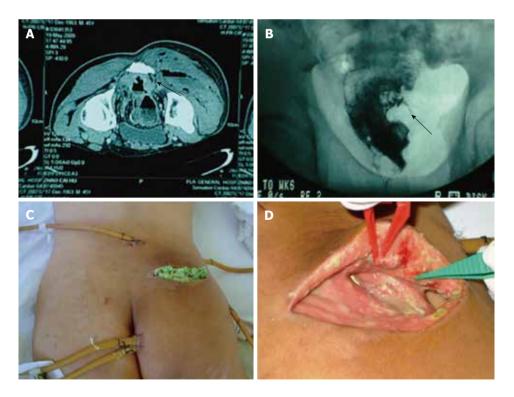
Computed tomography scan showing that the infection of the right hip had close relationship with rectum (arrow) (A); barium enema examination showed the fistula toward the right hip (arrow) (B); and placement of incisions and drainage tubes (C); and debridement and dressing change (D).
